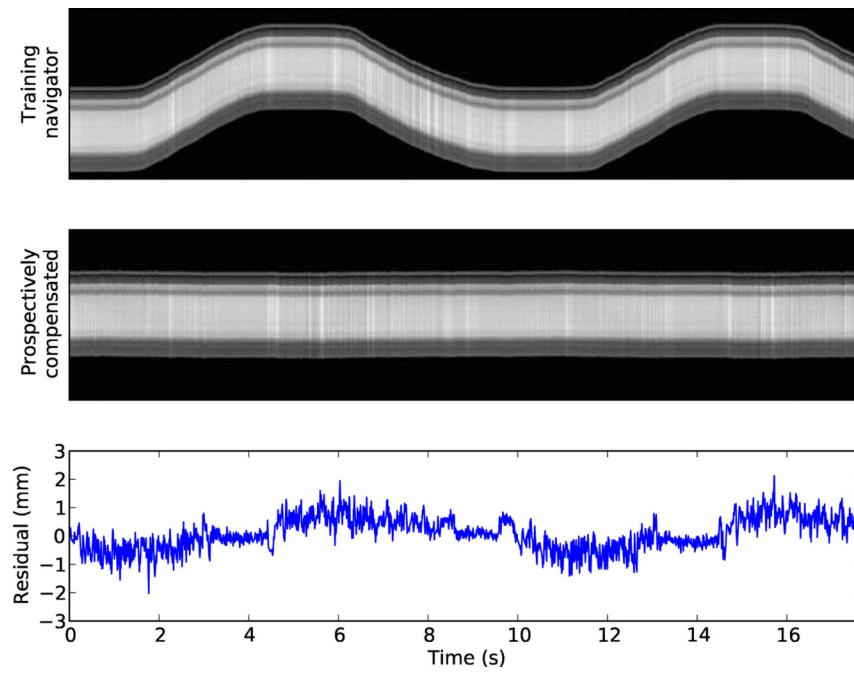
The top image shows the MRI training data used to compute the mapping table. The middle image shows the result when the same pulse sequence is performed under prospective navigation from this mapping table. The lower plot shows the residual position error in the middle image.
